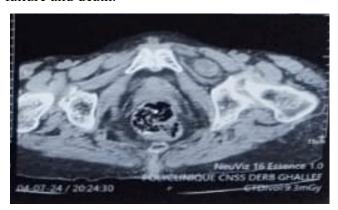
Abdominal computed tomography, axial section showing a left obturator hernia (*)
